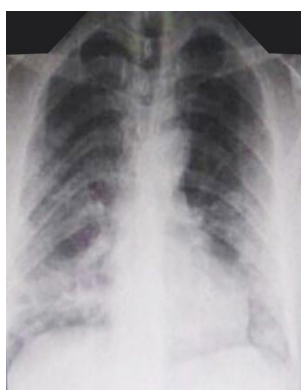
Chest X-ray during admission
